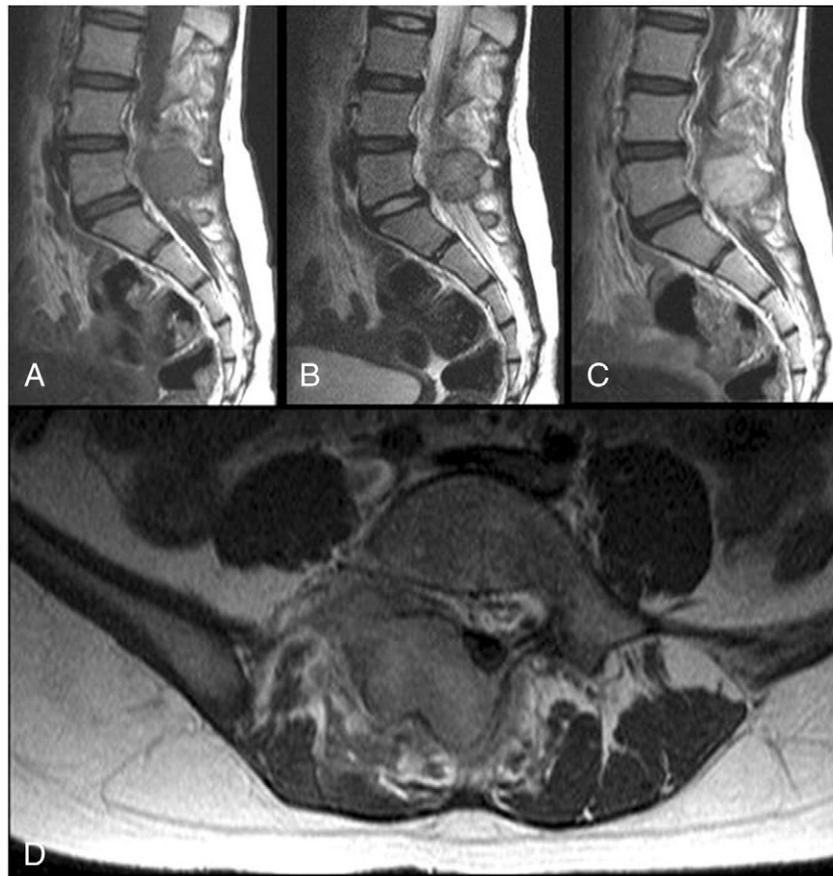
A 12-year-old female patient with spinal osteoblastoma. On sagittal T1-weighted (A) and T2-weighted (B) magnetic resonance images, hypointense expansile lesions in the right lamina and spinous process of the 5th lumbar vertebra were observed. On contrast-enhanced T1-weighted sagittal (C) and axial (D) magnetic resonance images, the lesion and the perilesional reactive soft tissue inflammatory changes were enhanced.
